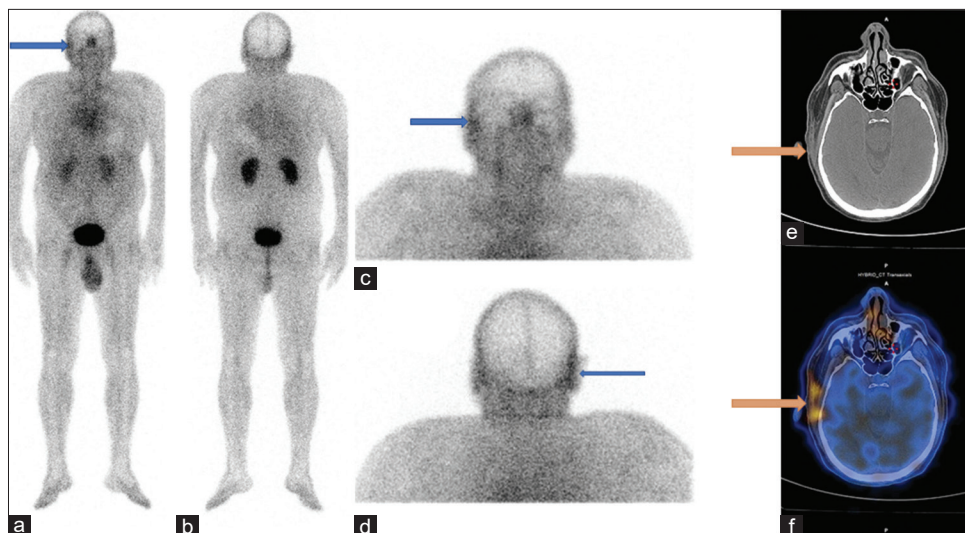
^{99m}Tc-UBI scan whole body (a-b), spot (c-d) and CT (e), SPECT/CT (f) images show an increased radiotracer uptake in soft tissue thickening at the posterior and inferior margins of the postoperative cavity in the right mastoid region
